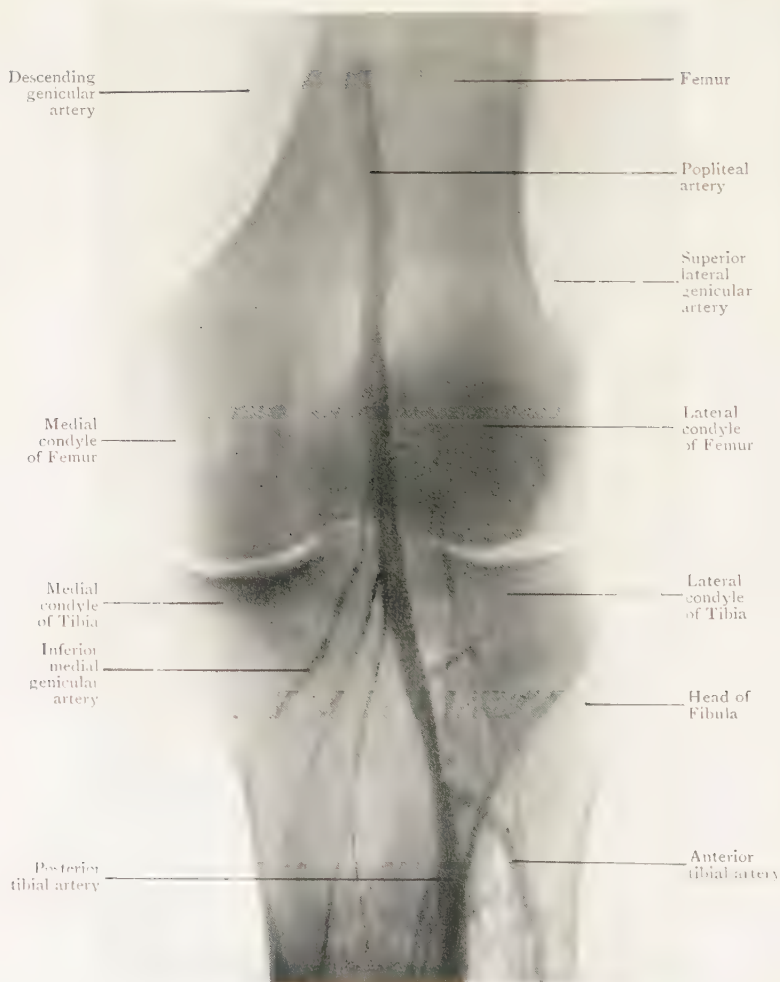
Antero-posterior radiograph of the Knee of an injected Lower Limb.
